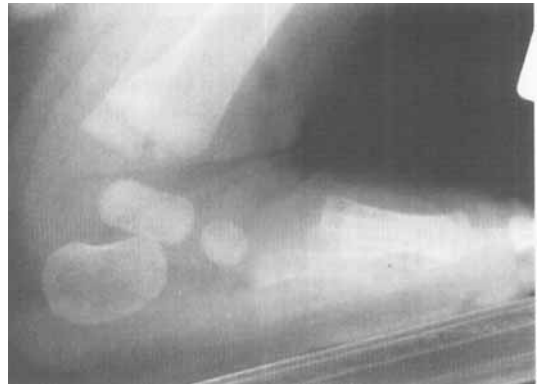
Anteroposterior and lateral radiographs of a well corrected clubfoot at age 4 months. This foot needs no surgery at all.
